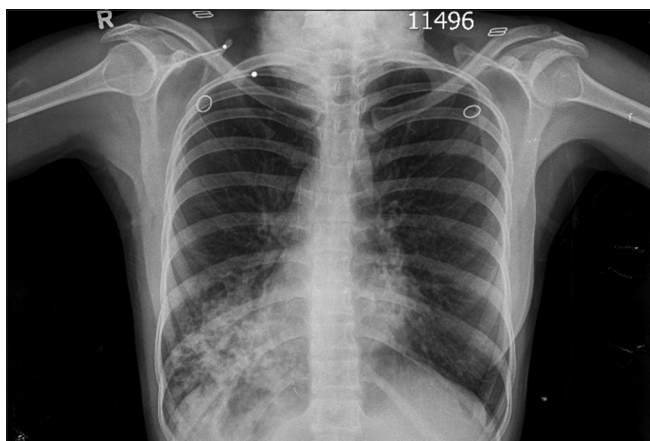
Chest X-ray showing dextrocardia with situs inversus. There are also ring shadows in both the lungs suggestive of bronchiectasis
